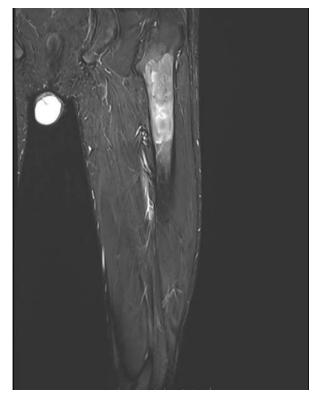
MRI Thigh muscles STIR image suggestive of Fibrous Dysplasia of left Femur bone
